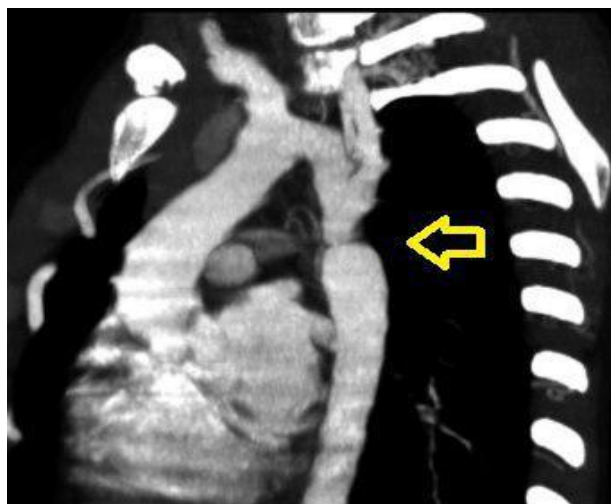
computed tomography (CT) scan in sagittal view showed CoA in neonate.
